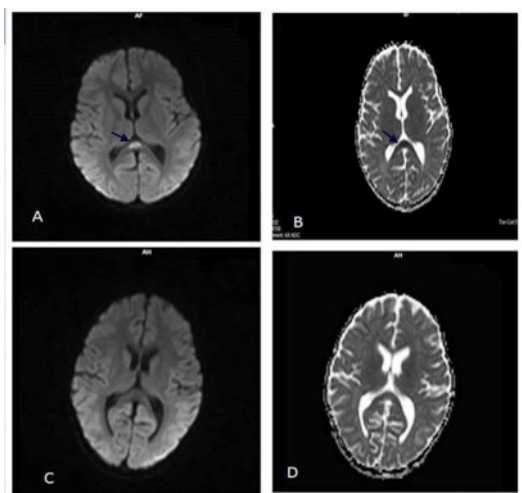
(Figure A and B). DWI and ADC map show restricted diffusion on the splenium (arrows). (Figure C and D). Follow up DWI and ADC map show complete resolution on the lesions in the splenium
